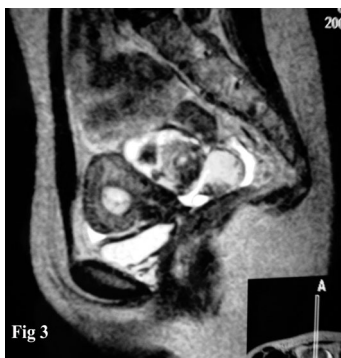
Complicated urinogenital abnormality in a 15-year-old girl with primary amenorrhea, cyclic pelvic pain, and urinate leakage. Sagittal T2-weighted fast SE image (TR/TE, 4500/120) showed normal uterus with thickened endometrium. The cervix was short, the upper portion of vagina was seen, and the distal portion of the vagina was absent. There was a little pelvic effusion. No fistula between the urethra and the vagina was seen. Vaginal atresia and urethra sphincter agenesis was found at surgery
